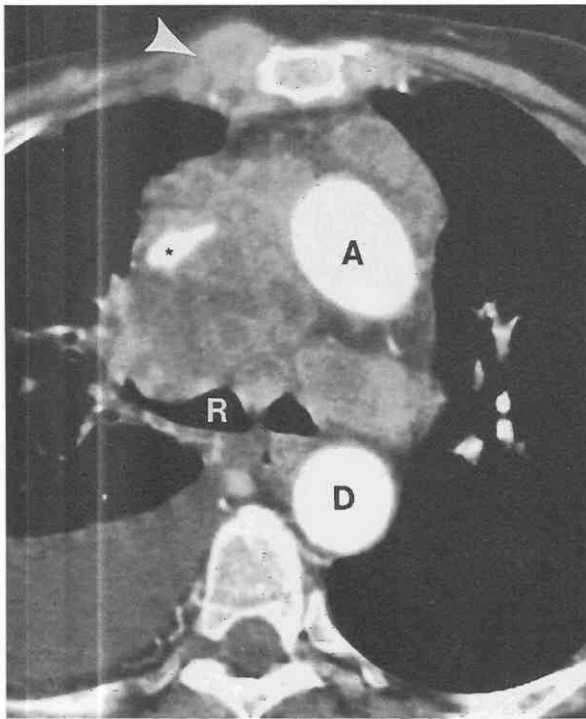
Diffuse mediastinal metastases. Contrast-enhanced CT shows diffuse infiltrating mediastinal mass caused by metastatic breast carcinoma. Narrowing of the superior vena cava (asterisk), chest wall metastasis (arrowhead), and large right pleural effusion can be seen. A, ascending aorta; D, descending aorta; R, right main bronchus.
